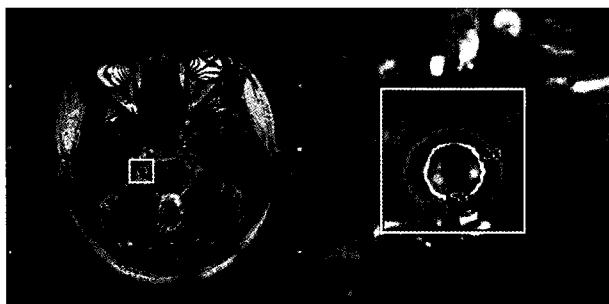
Short-range three dimensional magnetic resonance image technique demonstrates that left superior cerebellar artery is compressing trigeminal nerve root (arrow).
